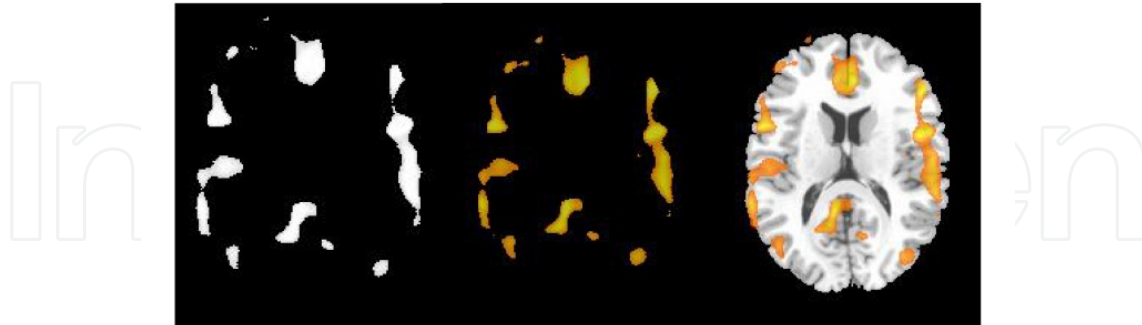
From left to right: original statistic map, colored statistic map and overlay over a T1 axial MR image.
